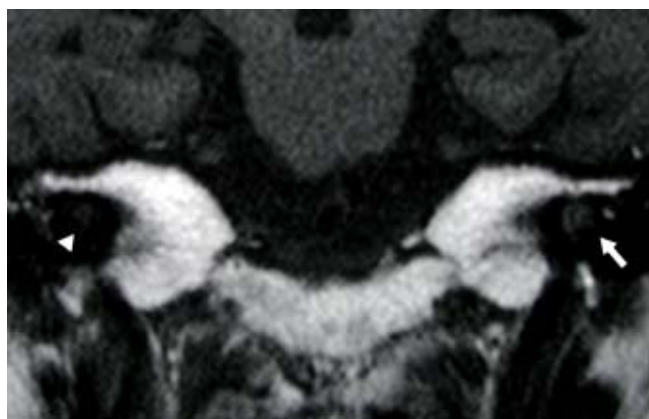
Unenhanced T1-weighted coronal images showing high signal from the left cochlea (white arrow). The right cochlea shows normal signal, which is isointense to the cerebrospinal fluid (white arrowhead).
